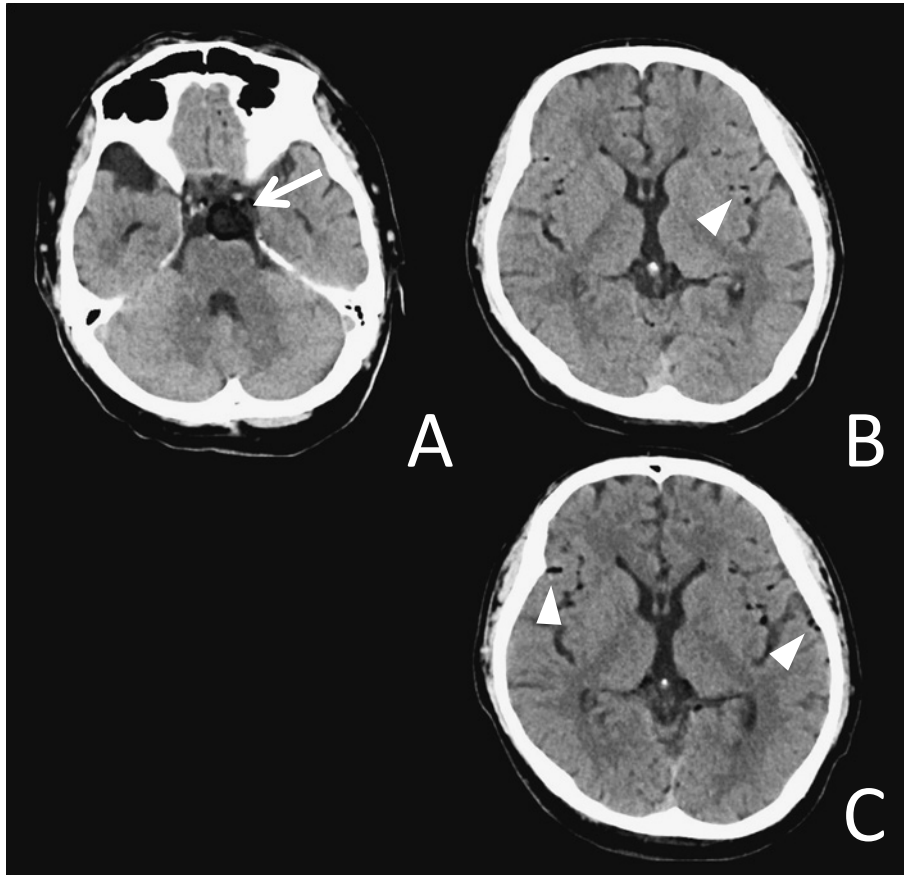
Preoperative brain CT.
